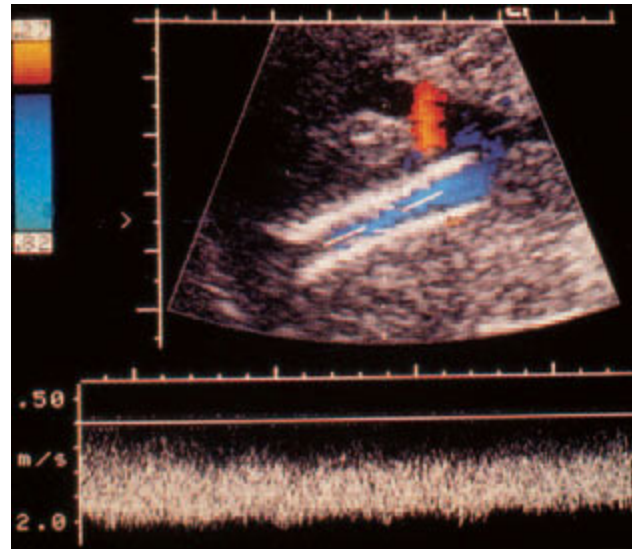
Doppler US scan showing blood flow (blue) through a TIPS shunt.
